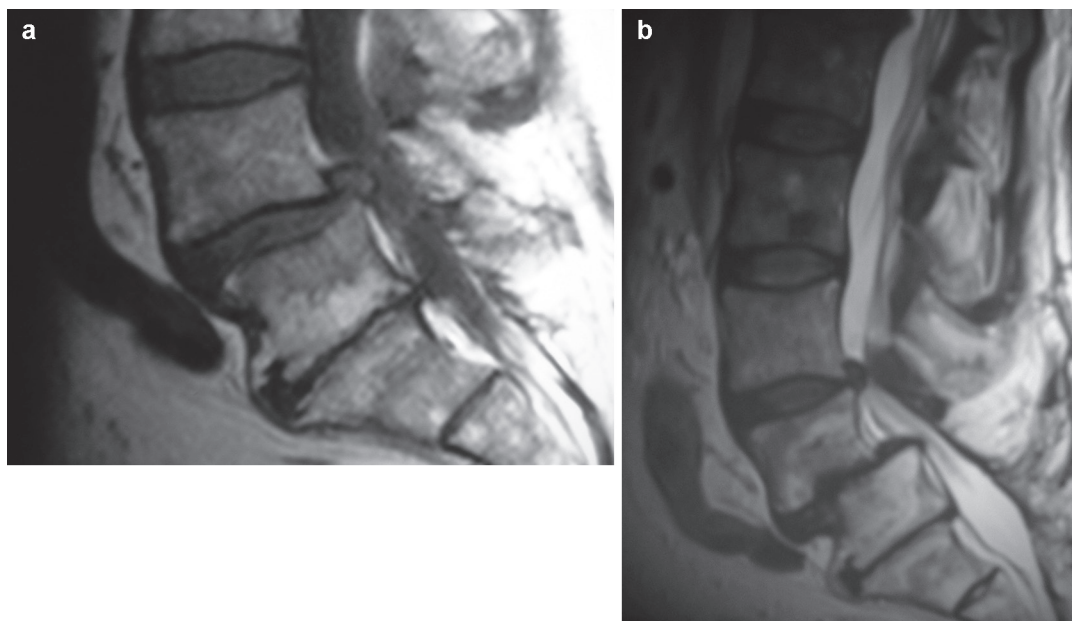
Iatrogenic progressive L4/5 spondylolisthesis after lumbar laminectomy. (a) T1-weighted MRI prior to laminectomy; (b) T2-weighted MRI post-laminectomy
